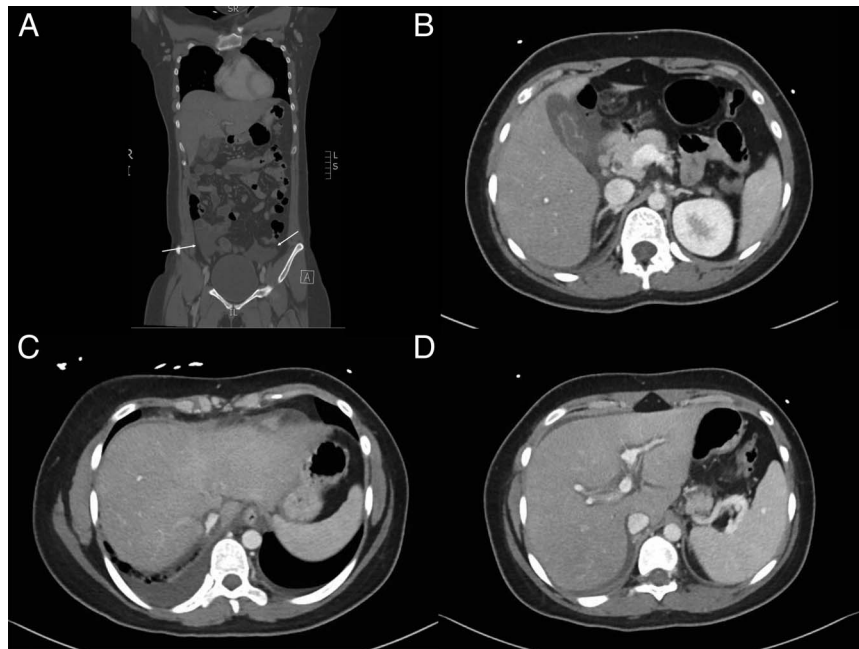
Abdominal computed tomography showing (A) moderate ascites, which is most prominent in the pelvic area (see arrows) in coronal view, (B) pericholecystic fluid, (C) bilateral pleural effusions, right greater than left, and (D) periportal effusion, seen as areas of hypoattenuation around the portal vein branches, and a normal-appearing liver.
